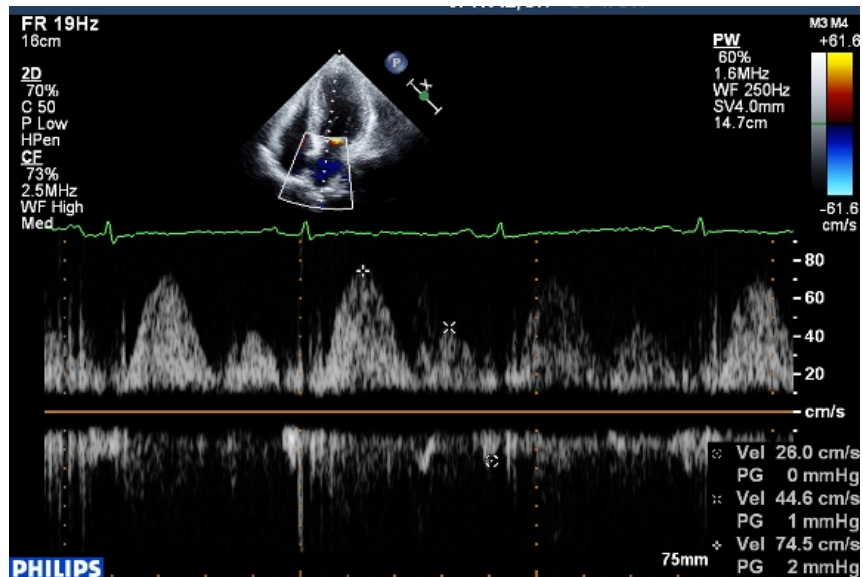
pulse wave doppler across pulmonary vein showing S-74.5cm/s and D-44.6cm/s with S/D ratio of more than 1, which is normal.
